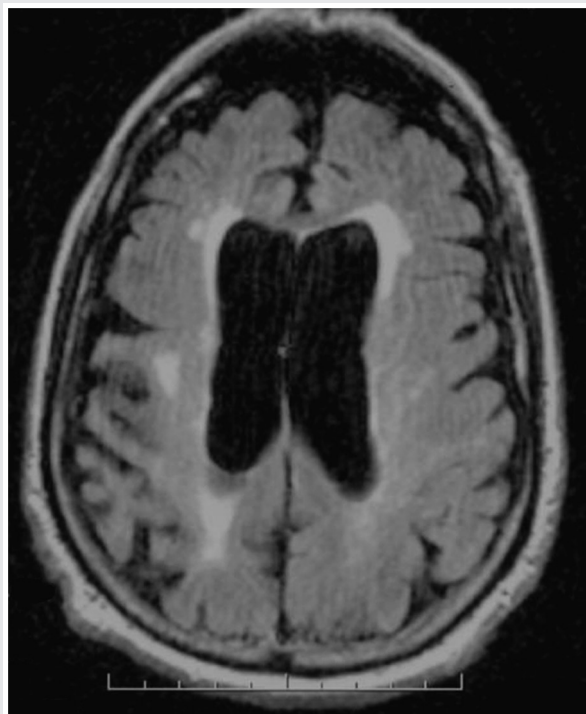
Axial fluid-attenuated inversion recovery (FLAIR) brain MRI showing asymmetric hemispheric atrophy, predominantly right parietal, in a patient with corticobasal syndrome due to Alzheimer disease pathology.
